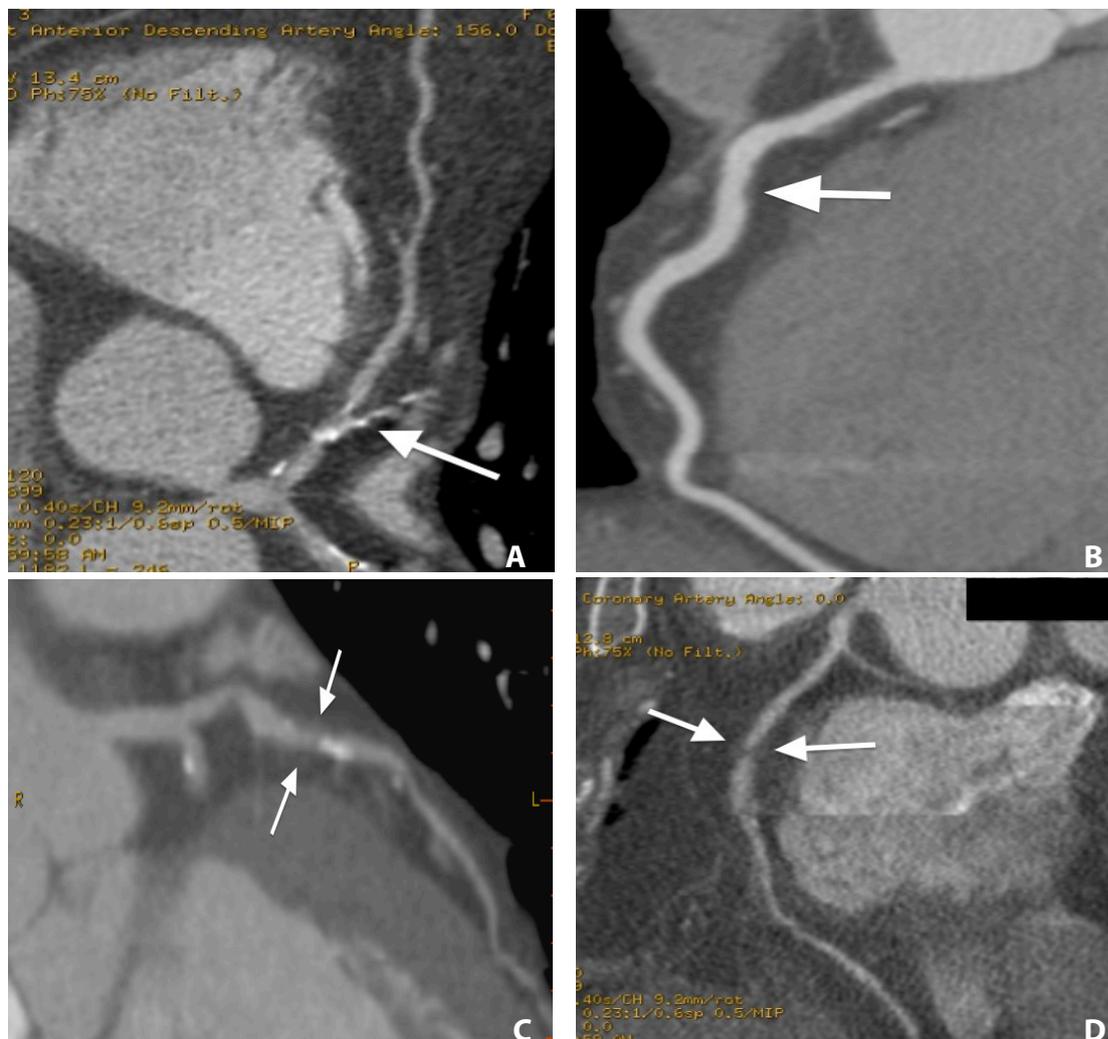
Coronary CT angiography scan, curvilinear reformats. A) Calcified significant plaques (arrow) in proximal left anterior descending and first diagonal arteries. B) Non-significant small non-calcified plaque in proximal right coronary artery (arrow). C) Mixed significant plaque (arrows) in the left anterior descending artery. D) Significant non-calcified plaque (arrows) in the right coronary artery.
